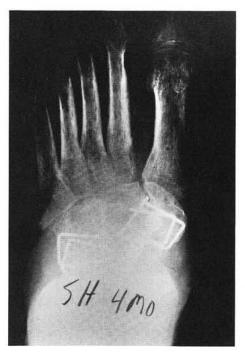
Radiographic evidence of solid bony union, one month after removal of cast. Note some minor improvement in osteopenia.
